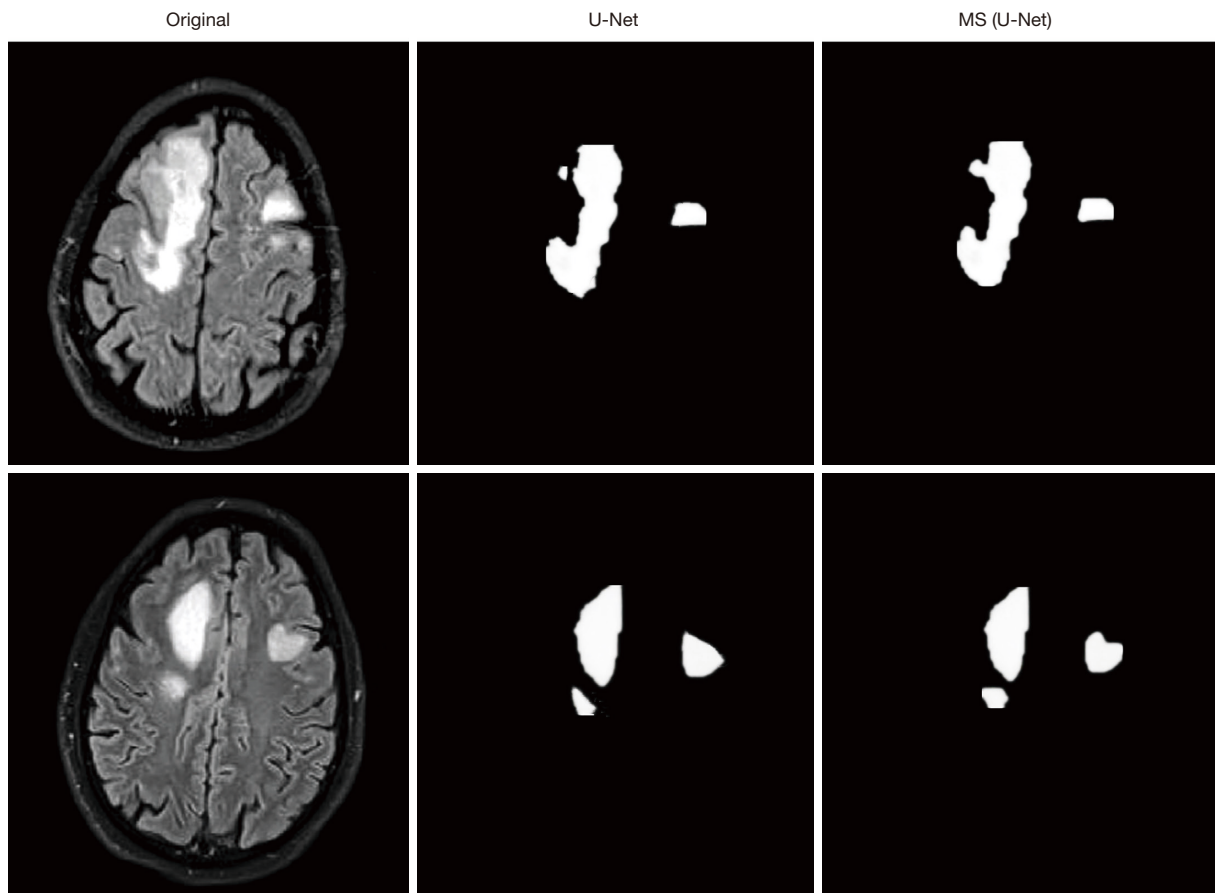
Comparison of segmentation effects of MRI of the brains of vertigo patients. MRI, magnetic resonance imaging; MS (U-Net), multiscale U-Net.
